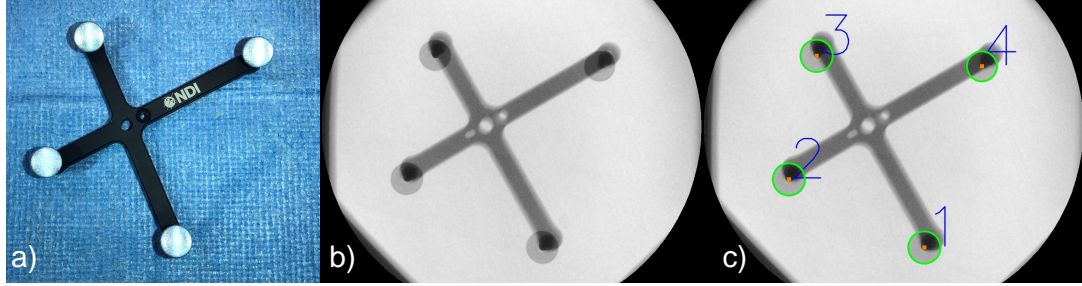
a) A photograph of the marker used for offline calibration of the system. Its 3D geometry, and in particular the location of the 4 infrared reflective spheres, is precisely known enabling 3D pose retrieval via outside-in optical tracking. b) An X-ray image of the same marker with c) detected centroids of the spheres. When the marker is stationary, poses extracted from a) and c) enable calibration of the optical tracker to the C-arm source as described in Section 2.2.
